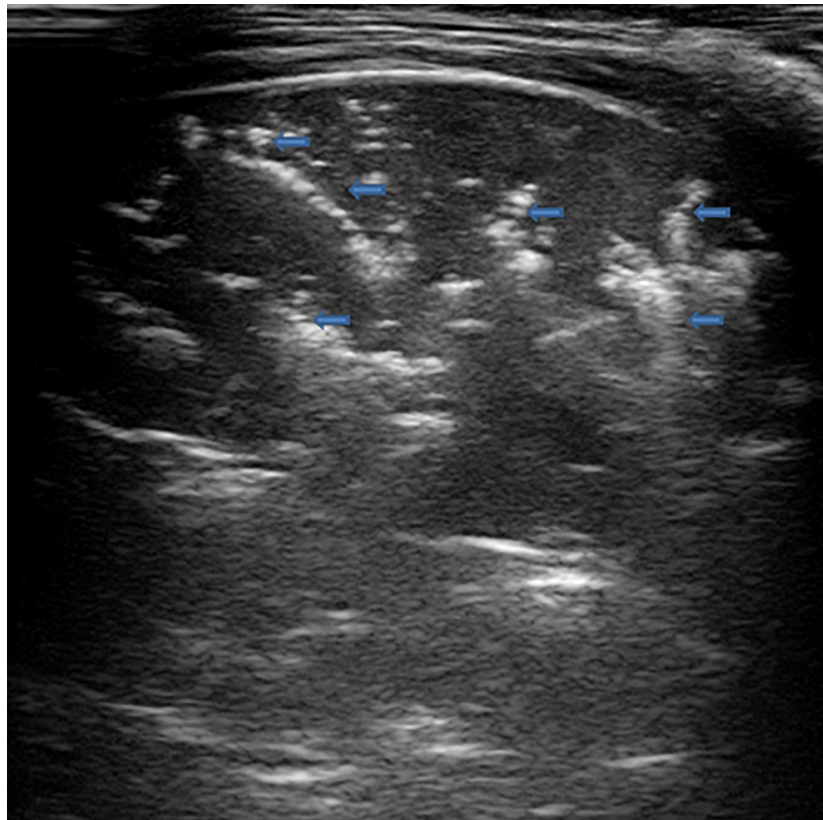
Grayscale lung ultrasound examination (transverse scan between intercostal fields; linear probe with 12 MHz frequency) of a 7-year-old boy with bacterial lobar pneumonia, shows hepatized subpleural consolidation with fluid bronchograms (arrows) and fibrinous inflammatory reactive pleural effusion (asterisk).
